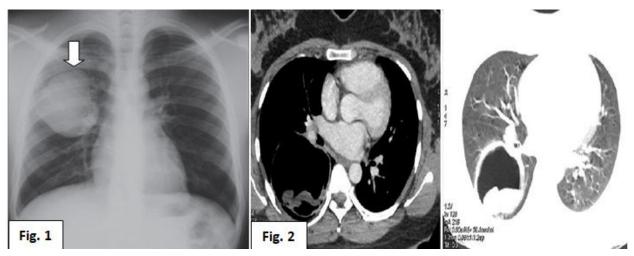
Pulmonary hydatid cyst at the level of the right upper lobe - homogeneous, oval, subcostal intensity, clearly delimited (white arrow). (1) Figure 2: CT chest mediastinum and lung window - highlights a cystic formation in the lower right lobe that contains floating endochistic membranes (the sign of ''lily flower''). (2)
